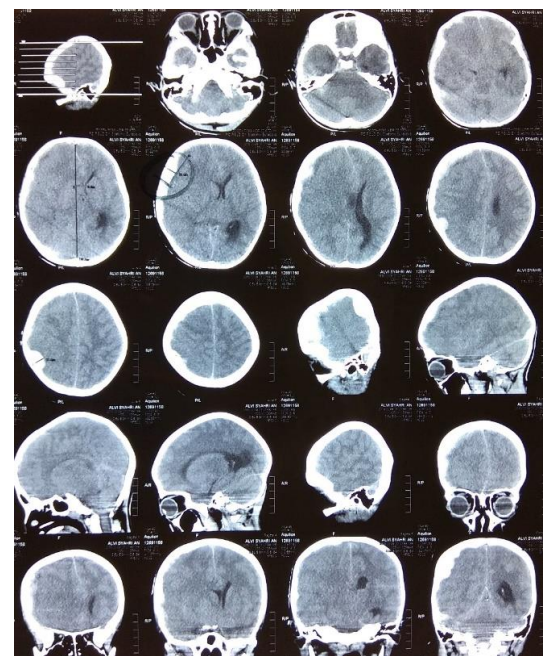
The CT Scan of Patient's Head Sagittal and Coronal View
